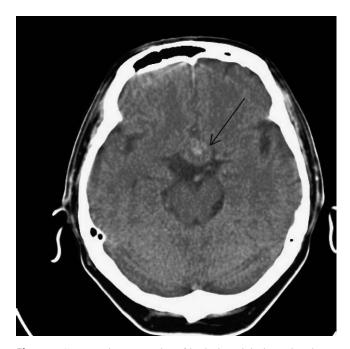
Computed tomography of brain in axial plane showing a pituitary mass lesion.
